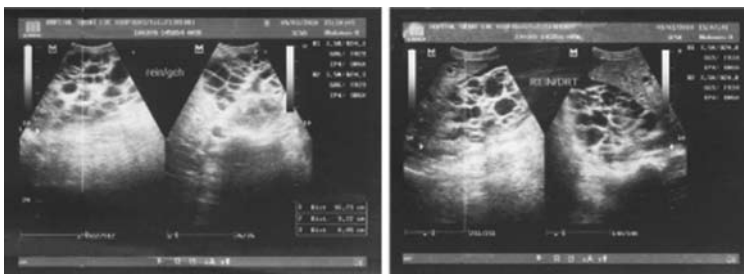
Sonographic pictures of ADPKD patient kidney.
